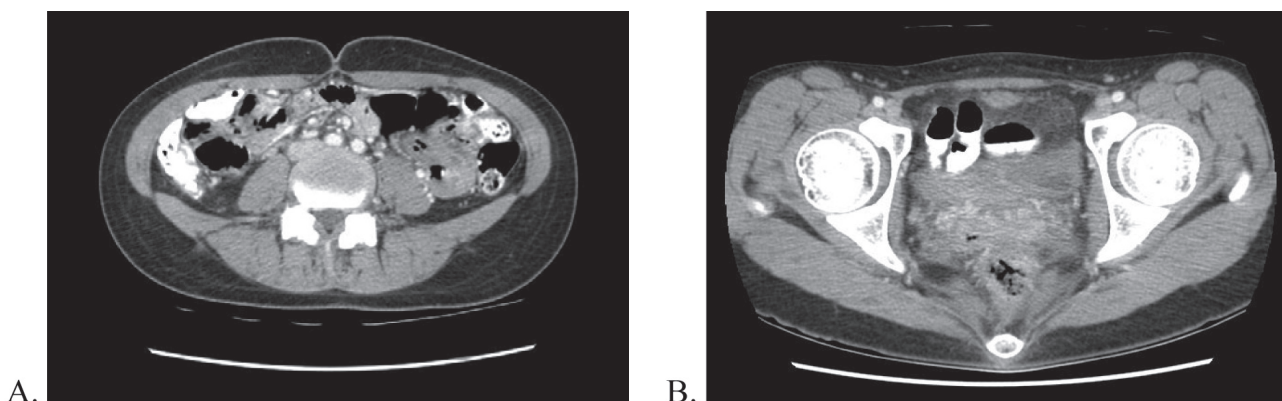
CT scan shown (A) circumferential wall thickening at ascending colon and cecum with (B) focal fat stranding at pelvis cavity
